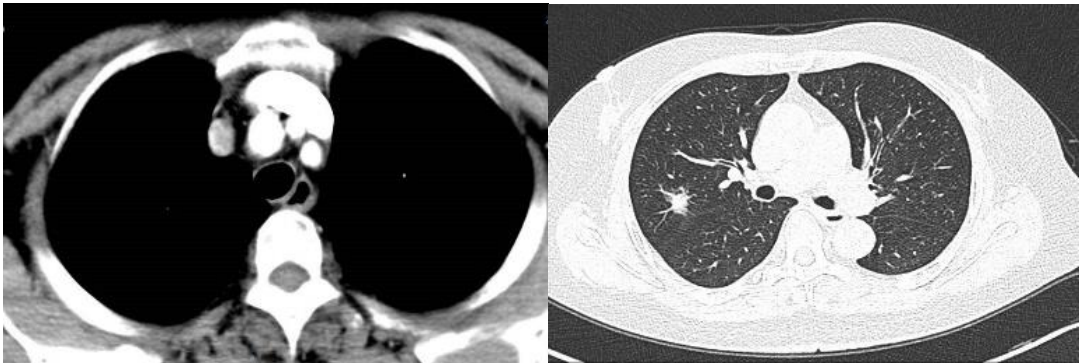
Preoperative chest CT (L, mediastinal window; R, pulmonary window)
